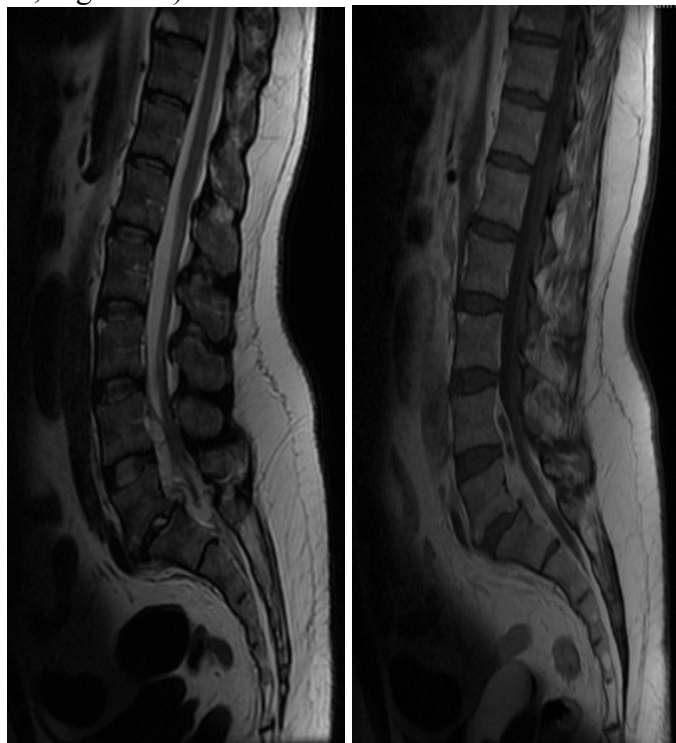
Sagittal T2-MRI of the lumbosacral spine
